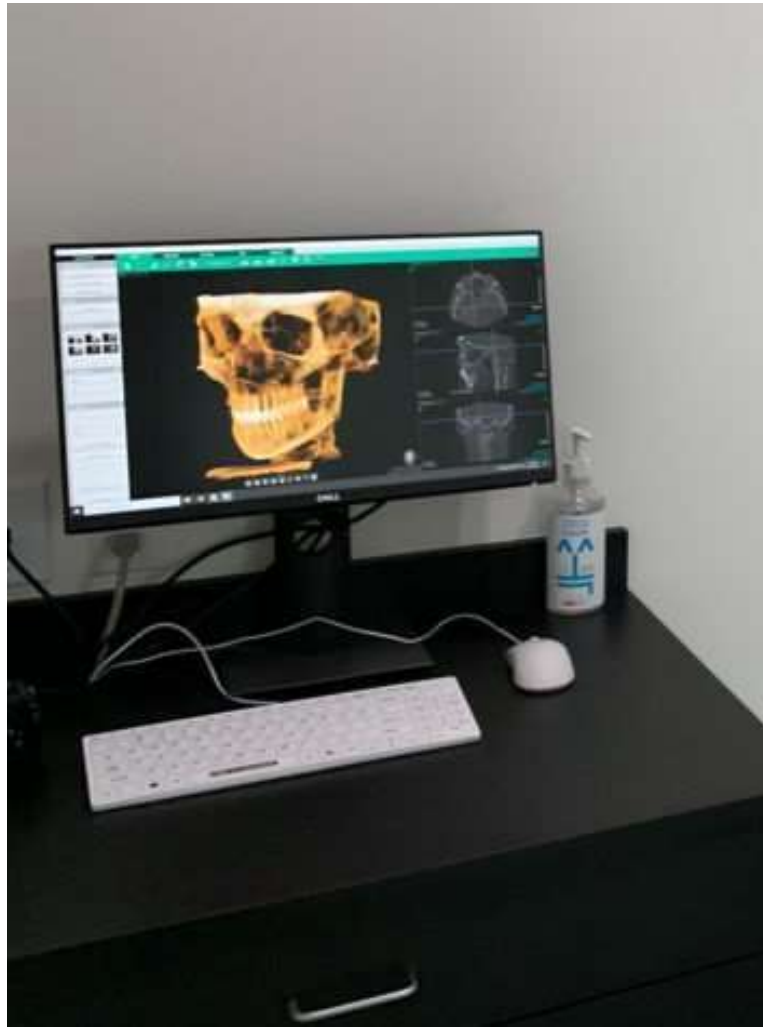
computer screen showing CBCT image
